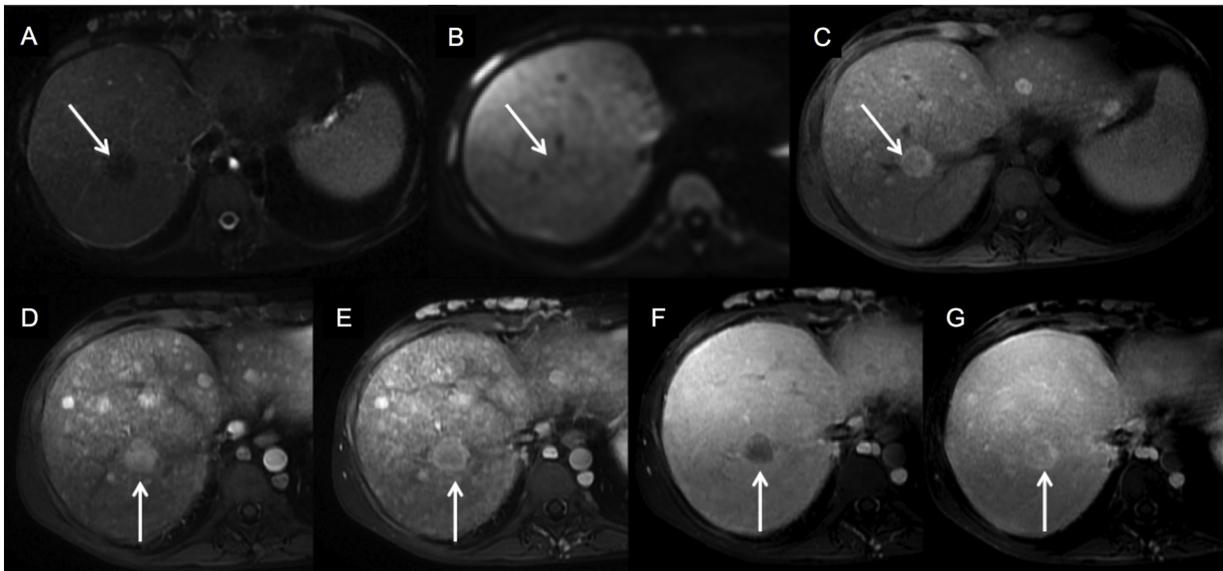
FNH-like RN mimicking HCC. MRI obtained after intravenous bolus injection of gadobenate dimeglumine show a regenerative nodule (arrow) hypointense on T2 (a), isointense on diffusion weighted imaging (DWI) (b), hyperintense on T1 (c), hyperenhancing on arterial phase (d) (enhancement was also seen on subtraction image, not shown) and portal phase (e) and with wash-out on delayed phase (f) mimicking HCC. On hepatobiliary phase (g) the lesion appears inhomogeneously isointense-hyperintense to normal liver. This helps to differentiate FNH-like RN from HCC.
